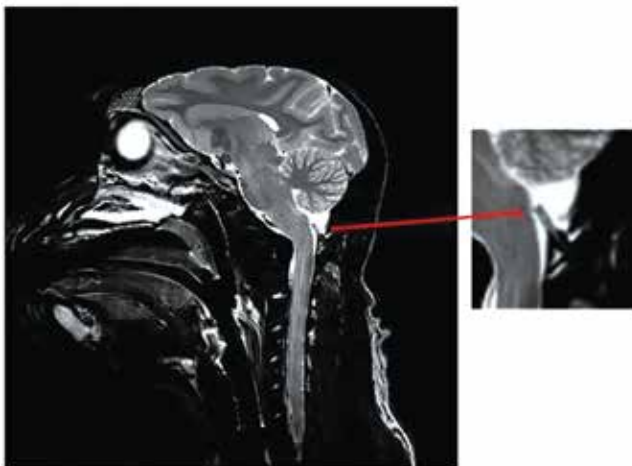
MR image showing a slight depression on the brain stem due to the physical presence of the 1.0-cm silicone catheter tip.
